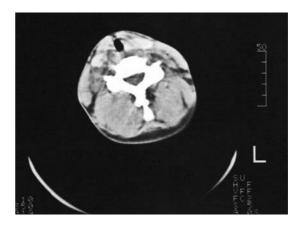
Computed tomography (CT) image of the tracheal lumen below the glottis
